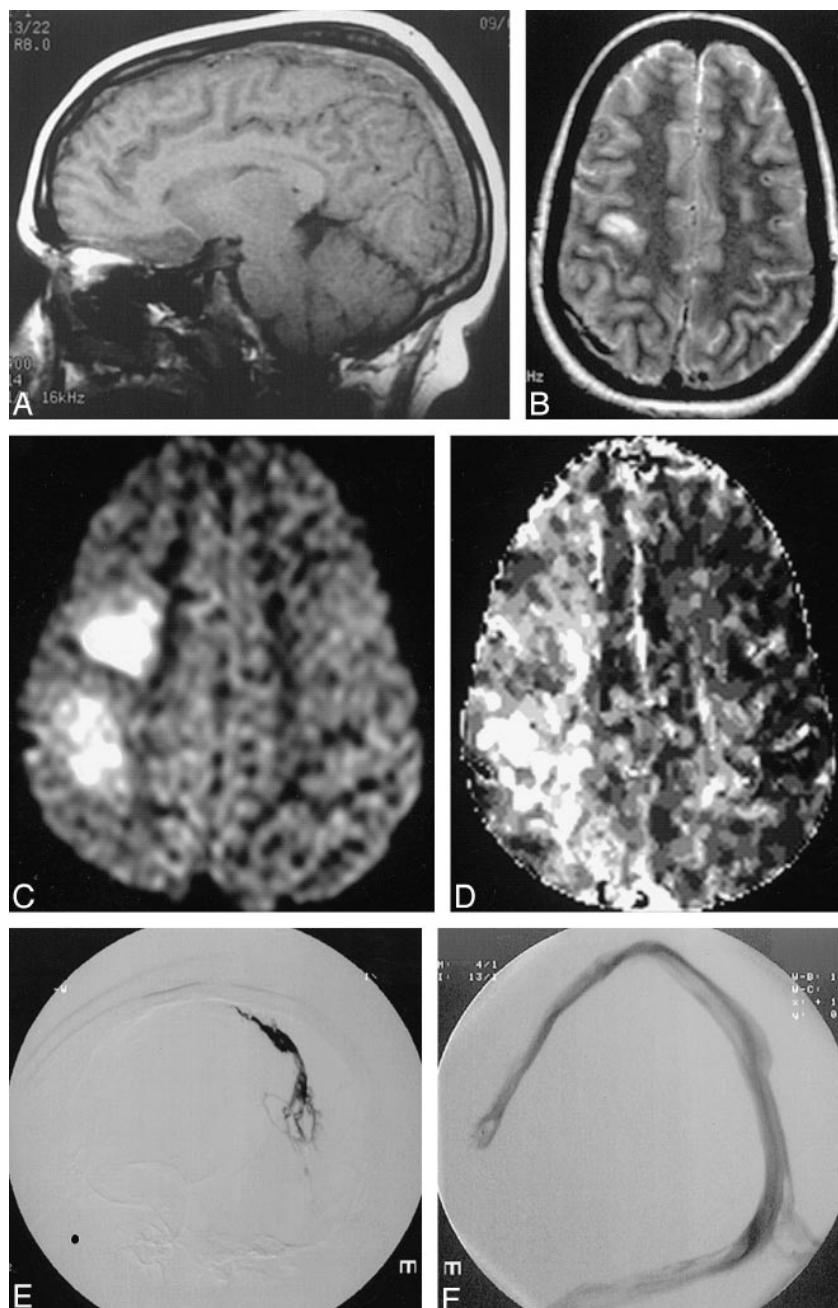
A, Sagittal T1-weighted image showing thrombus in the superior sagittal sinus.
